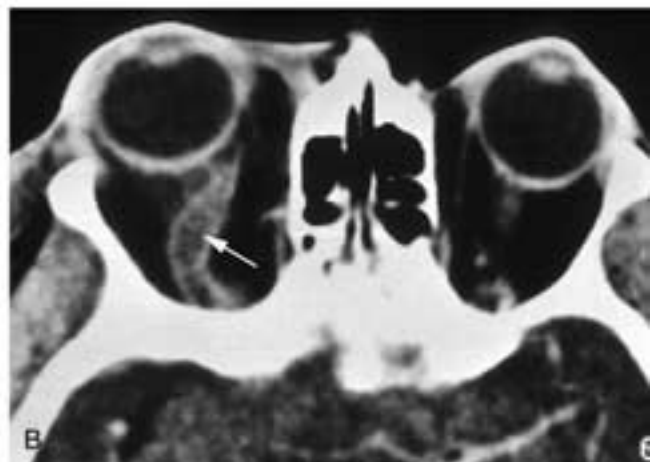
Thrombosis of the cavernous sinus. Postcontrast axial CT scan. A, There are filling defects (arrows) in places normally opacified in the cavernous sinus. B, There is a defect (arrow) filling the superior orbital vein. (Courtesy of Bernard Schuknecht, Zurich.)
